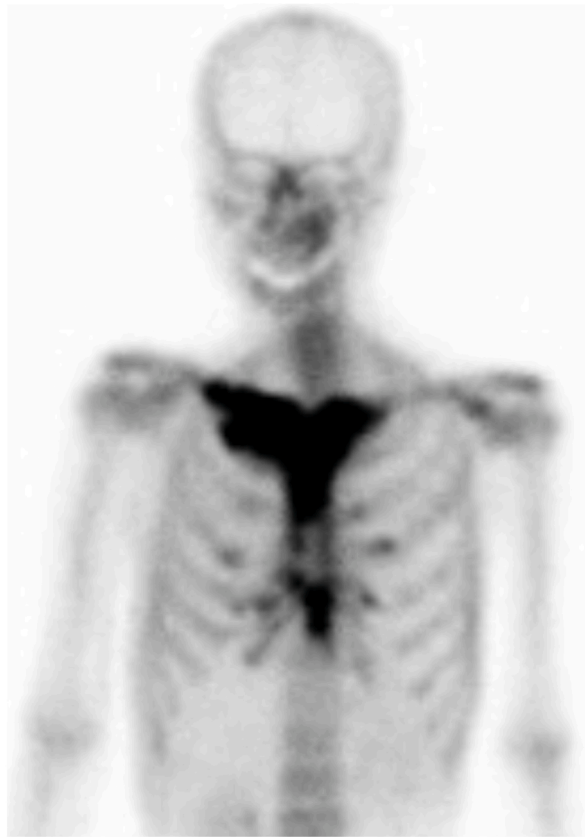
Bone scintigraphy showed symmetric uptake in the sternoclavicular region. This represented a focal osteogenic reaction, called the “bull’s head sign,” a characteristic sign of SAPHO syndrome.
